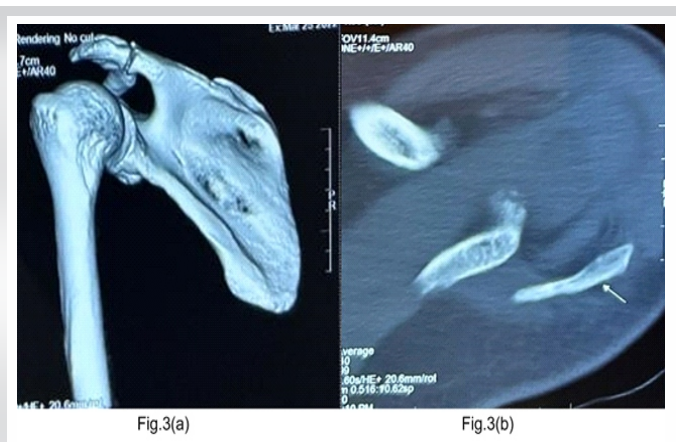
(a) 3D reconstructed image of scapula showing the fracture. (b) A curvilinear calcific lesion seen in the computed tomography axial cuts.
